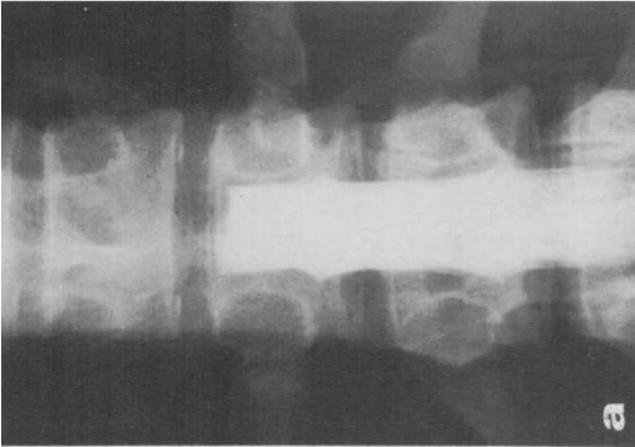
a-e. Extramedullary (intradural) tumor location: Two adjacent thoracic neurinomas. a Ascending metrizamide myelogram showing total block at upper of D 11; exact position of spinal cord relative to space occupying lesion difficult to evaluate. b, c CT scan at the level of the upper portion of D 10 after intravenous bolus enhancement (two different window settings, scan performed during deep inspiration) showing upper neurinoma; spinal cord extremely flattened and posteriorly displaced (c, *arrow*). d Scan at the level of the lower portion of D 10 after intravenous bolus enhancement (performed during almost expiration) showing lower neurinoma. e Scan at level of D 12 with normal appearance of intraspinal soft tissues
